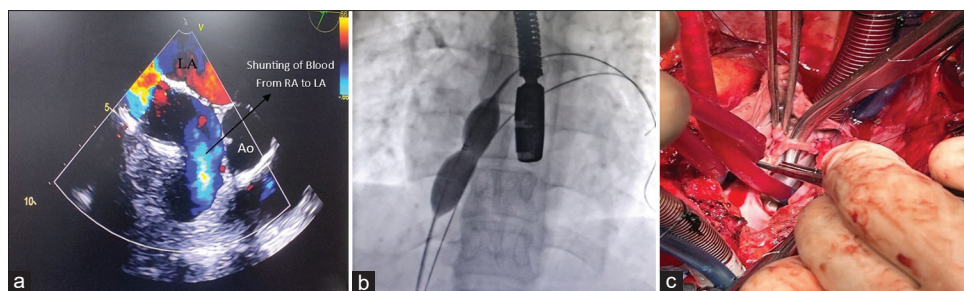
(a) Midesophageal 60° in transesophageal echocardiography showing deficient aortic margin (arrow) with a left-to-right shunt. (b) Balloon interrogation reveals two defects. (c) Surgery revealed two inferiorly located residual defects with degeneration of the patch. Ao: Aorta, LA: Left atrium, RA: Right atrium
